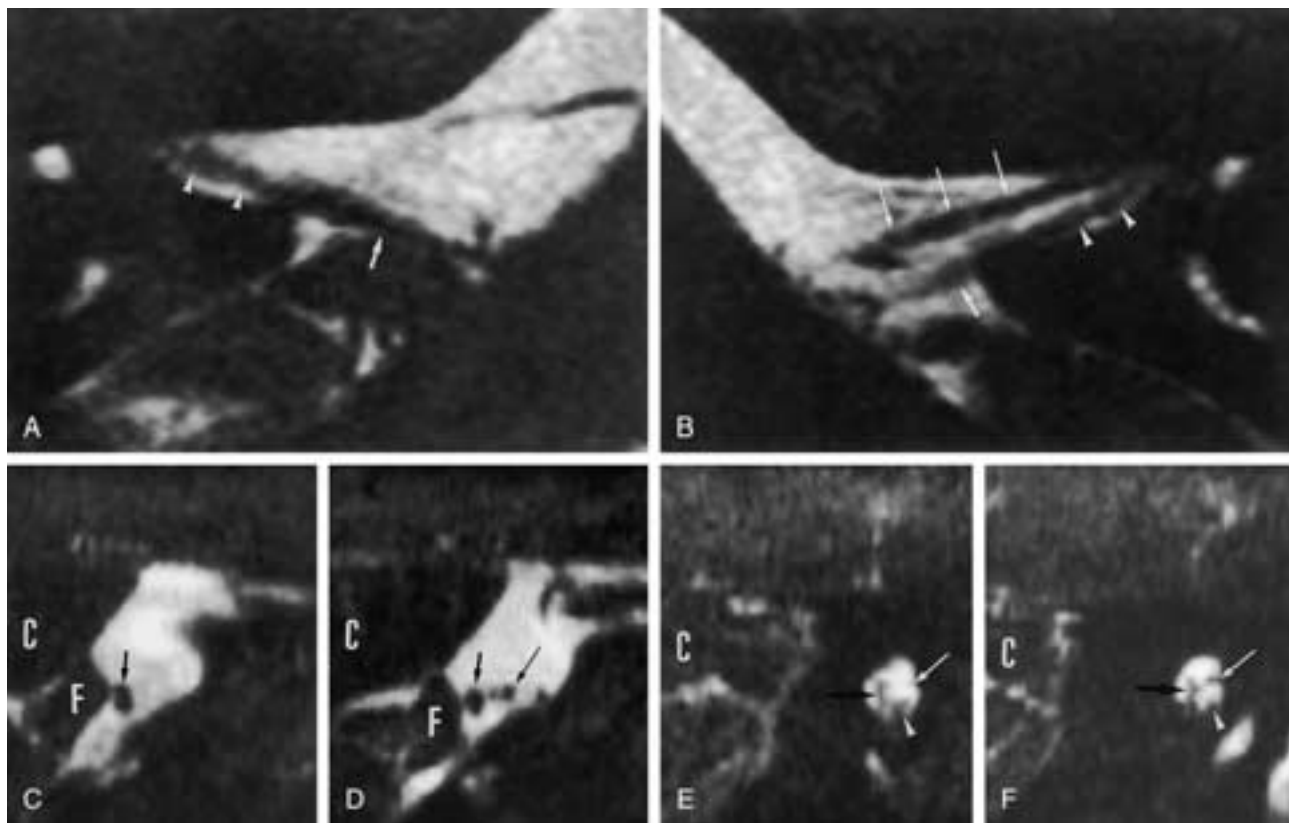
Aplasia of the right facial nerve in a patient with congenital facial nerve palsy. A and B, Axial 0.7 mm thick gradient-echo T2-weighted images through the right (A) and left (B) IACs. A, Only one nerve, the VCN, can be seen in the right cerebellopontine angle (small white arrow) and IAC (white arrowheads). B, The VCN can again be seen in the cerebellopontine angle (small white arrow) and IAC (white arrowheads). The facial nerve can be seen anterior to the VCN (long white arrows). C to F, Parasagittal 3DFT-CISS reconstructions perpendicular to the course of the nerves at the level of the right (C) and left (D) cerebellopontine angles and the right (E) and left (F) IACs. C, A large nerve, the VCN (small black arrow), can be seen in the right cerebellopontine angle, situated just anterior to the floccule. D, The facial nerve (long black arrow) and a larger VCN (small black arrow) can be seen anterior to the floccule on the left side. E, The common vestibular branch (large black arrow) and cochlear branch (white arrowhead) of the VCN have a normal appearance. The facial nerve cannot be found in the anterosuperior segment of the IAC (long white arrow). F, The cochlear (white arrowhead) and common vestibular (large black arrow) branches of the VCN can be distinguished in the middle one third of the IAC. The facial nerve also has a normal size (long white arrow). C, Cerebellum; F, floccule.
